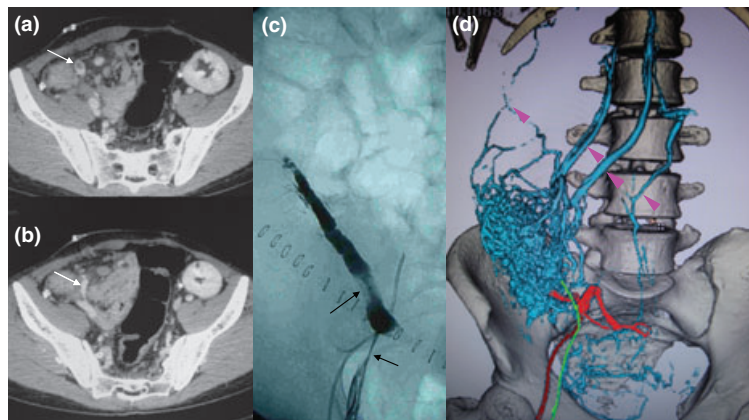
(a) Findings of enhanced computed tomography (eCT) on postoperative day (POD) 6. Partial thrombus in graft splenic vein (arrow) was detected. (b) Findings of enhanced computed tomography (eCT) on postoperative day (POD) 6. Patency of portal trunks (arrow) was preserved without thrombus formation. (c) Angiography for pancreatic graft on POD 14. Contrast medium was infused via the catheter (arrow) placed in splenic vein of the pancreatic graft after successful mechanical thrombectomy. (d) Findings of 3-D enhanced computed tomography (eCT) on POD 15. Contrast medium was infused via the arterial catheter placed in the Y-graft of the pancreatic graft. Red line showed the arterial catheter placed in the pancreatic graft through the right femoral artery. Red line also indicates the arterial Y-graft, graft splenic artery and superior mesenteric artery. Yellow-green line shows venous catheter placed in the graft splenic vein through the right femoral vein. Blue line indicates the venous flow of the graft including the mesenteric vein (pink arrow) of the recipient.
